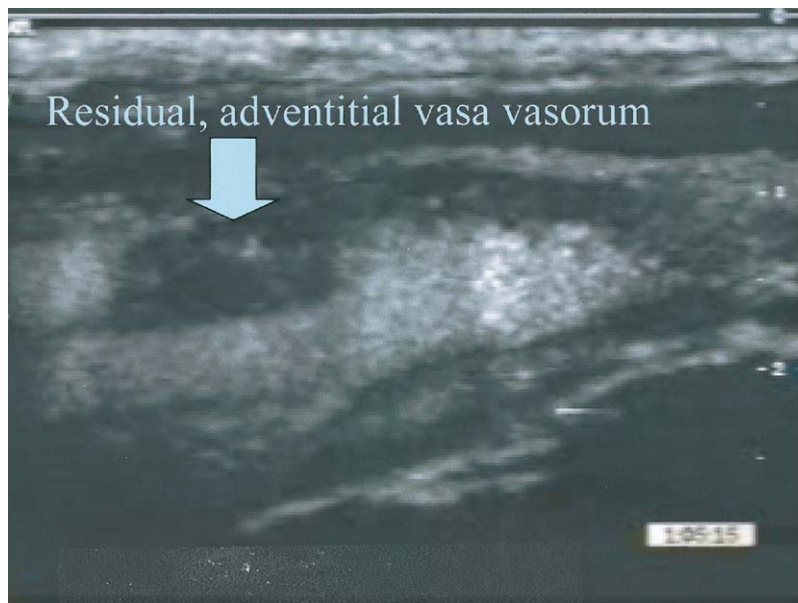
After 8 months of statin therapy, the patient (Fig. 6) returned for a follow-up contrast-enhanced carotid ultrasound examination. Note that the adventitial vasa vasorum vessel prominently seen in Figure 6 has been significantly reduced. This may represent regression of the adventitial vasa vasorum after antiangiogenesis therapy with statins.
